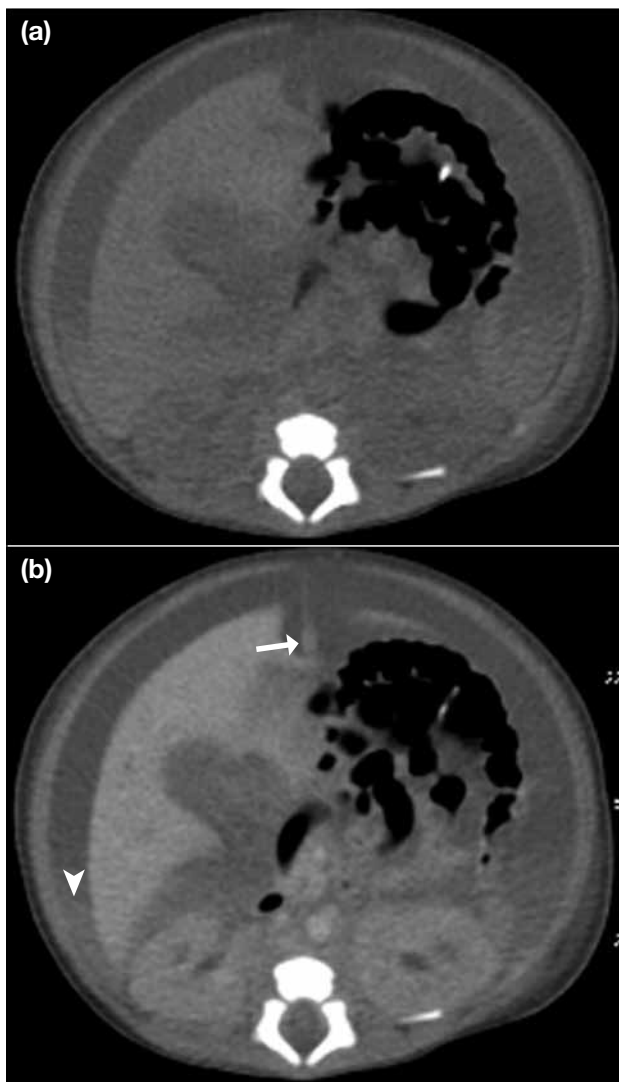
(a) Pre-contrast and (b) post-contrast computed tomographic abdomen: ascites with dependent hyperdense fluid level is seen, compatible with haemoperitoneum (arrowhead). The umbilical vein (arrow) appears patent below the level of liver. No pneumatosis intestinalis (suggestive of necrotising enterocolitis) is seen.
